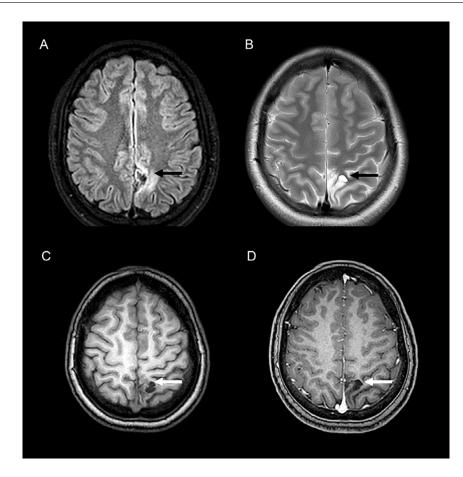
(A and B) MRI findings 1-year after starting treatment (intensive and prolonged continuation phase antituberculostatic treatments already completed). FLAIR and T2WI demonstrate sequelae signal changes (black arrow). Mass is no longer identified in the left parietal region. (C and D) T1WI without (C) and with contrast (D) injection. The area of contrast enhancement is no longer identified (white arrow).
